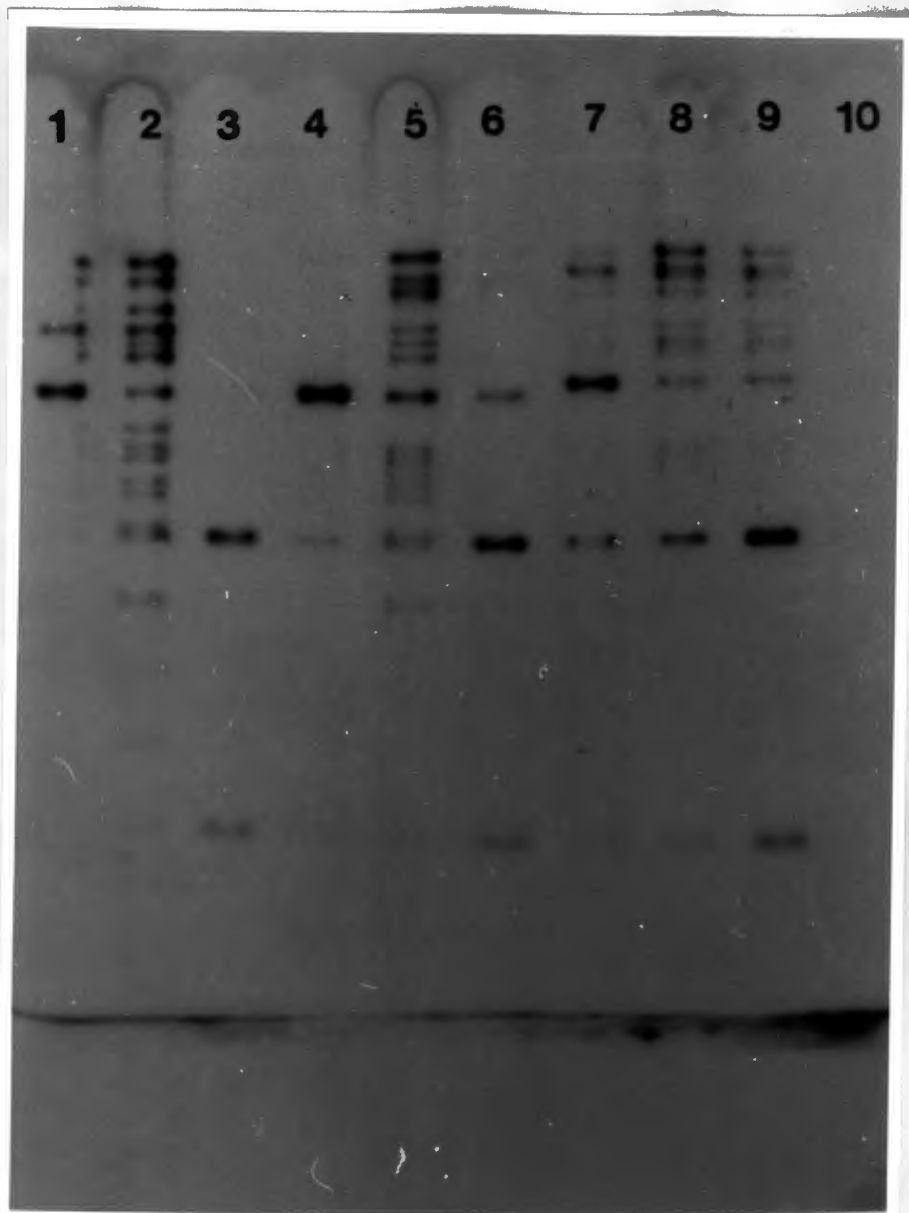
Autoradiograph of 3 monkeypox strains (Southern blot), hybridized to Mp Denmark Hind III probes. Lanes 1 - 3: Sq 249 Pst I; Lanes 4 - 6: Mp 266 Pst I; Lanes 7 - 9: Mp 82 Pst I; Lane 10: Mp Z 369 Pst I. Lanes 1, 4 and 7 were probed with ^{32}P -labelled Mp Denmark Hind III N cloned into pBR 329. Lanes 2, 5 and 8 were probed with ^{32}P -labelled Mp Denmark. Lanes 3, 6 and 9 were probed with ^{32}P -labelled Mp Denmark Hind III K cloned into pBR 329. Lane 10 was probed with ^{32}P -labelled pBR 329. The hybridizations were done in the deca-probe apparatus and the X-ray film exposed for 8 hours.
